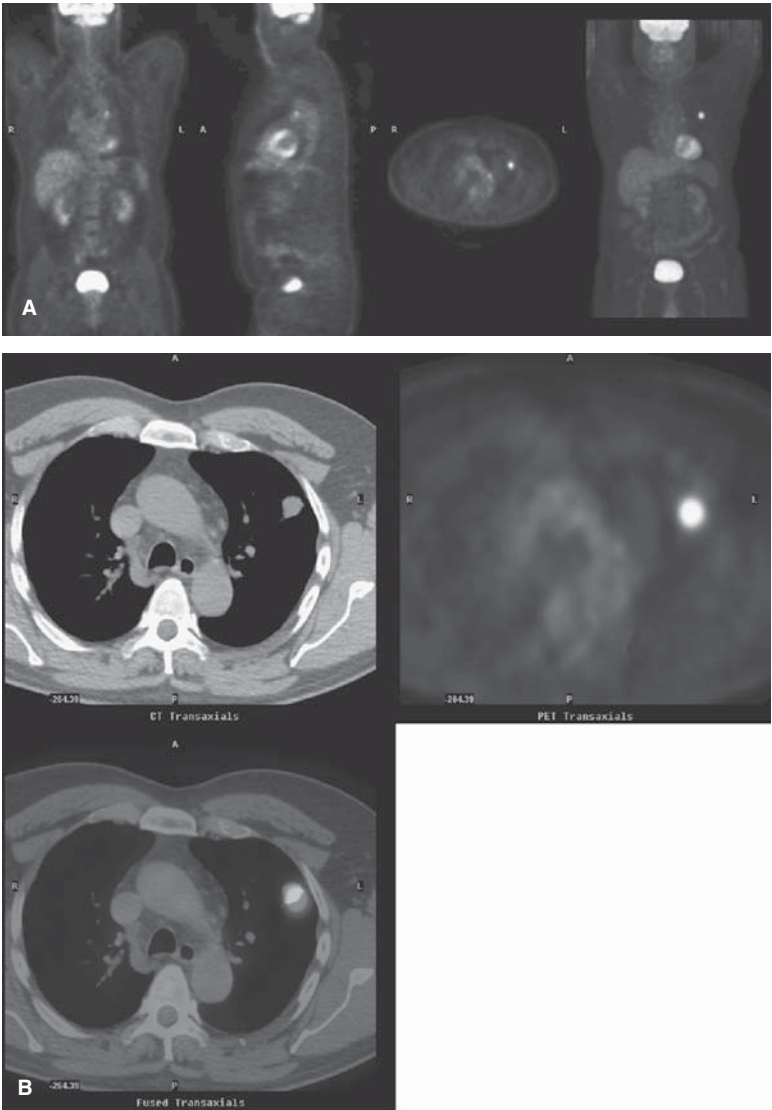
Solitary pulmonary nodule with ipsilateral hilar metastasis. (A) FDG-PET whole-body scan of another patient with a suspicious left upper lobe nodule which is hypermetabolic (SUV = 6) and highly suspicious for malignancy. A faint focus of increased activity is seen in the left hilar region. (B) Axial FDG-PET/CT images through the left upper lobe lesion demonstrate hypermetabolism consistent with malignancy.
